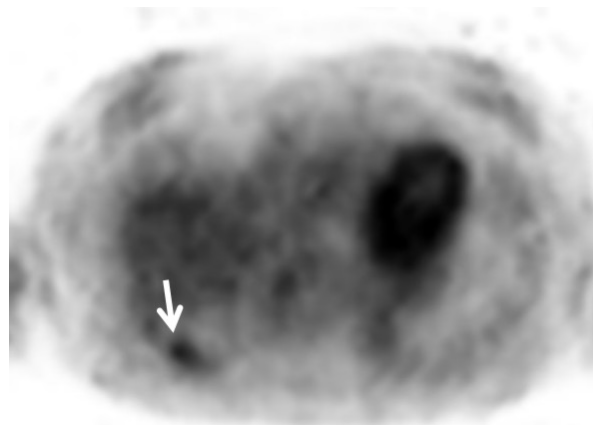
FDG-PET before lung resection showed abnormal uptake (SUVmax 3.2) at the site of the mass in the right lower lung field (arrow head).
